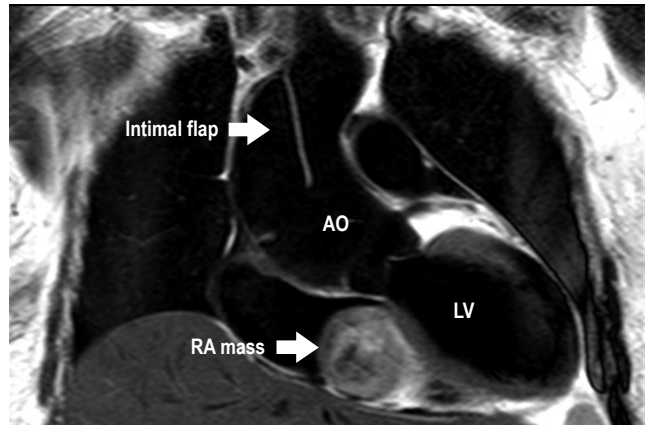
T2-weighted dark blood image, the RA mass showed hypersignal intensity. The central part of tumor showed mixed high and low (heterogenous) signal intensity on T2-weighted image represent hemorrhagic and necrotic tumor.
